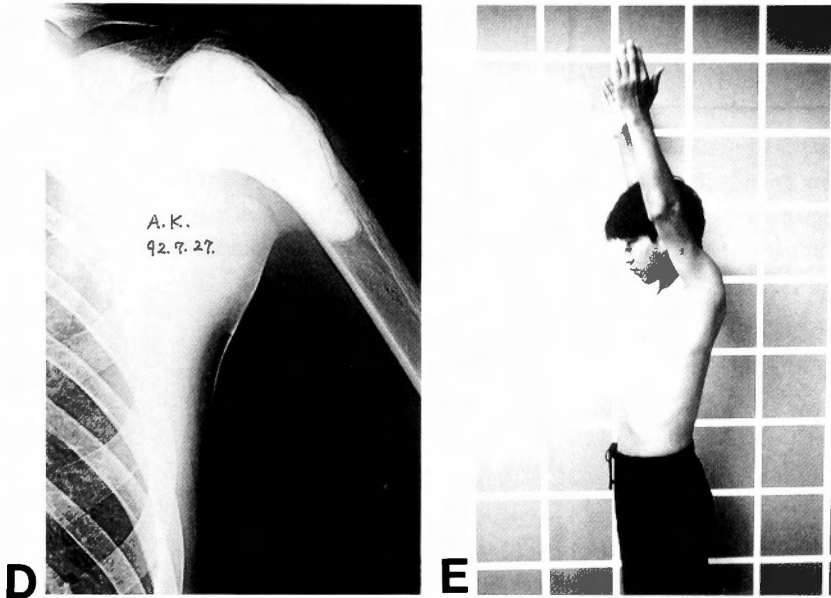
Case 8. 22 year old male. GCT at the proximal humerus was associated with a pathologic fracture (A). However, a bony shell was considered to be preserved until the operation was performed (B). On MR imaging study, an extraosseous extension could not be determined (C). X-ray taken at 23 months after the operation reveals 2 mm radiolucent zone around the plugged cement (D). According to a modified functional evaluation system, this case was rated as excellent (E).
